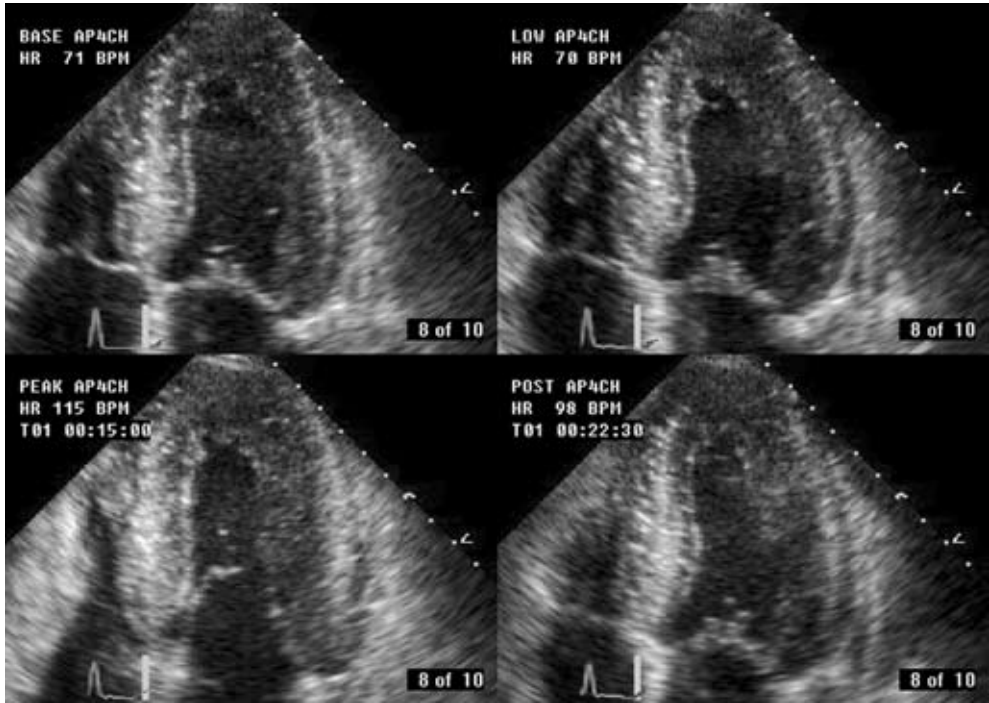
Example of a stress-induced wall motion abnormality on dobutamine echocardiography. Panels A, B, C and D are obtained during rest, low- (10 $\mu\text{g}/\text{kg}/\text{min}$) and high-dose dobutamine (40 $\mu\text{g}/\text{kg}/\text{min}$) and recovery. In the septal region (white arrow), normal wall motion is present at rest and during low-dose dobutamine infusion, whereas dyskinesia is induced at high-dose dobutamine.
